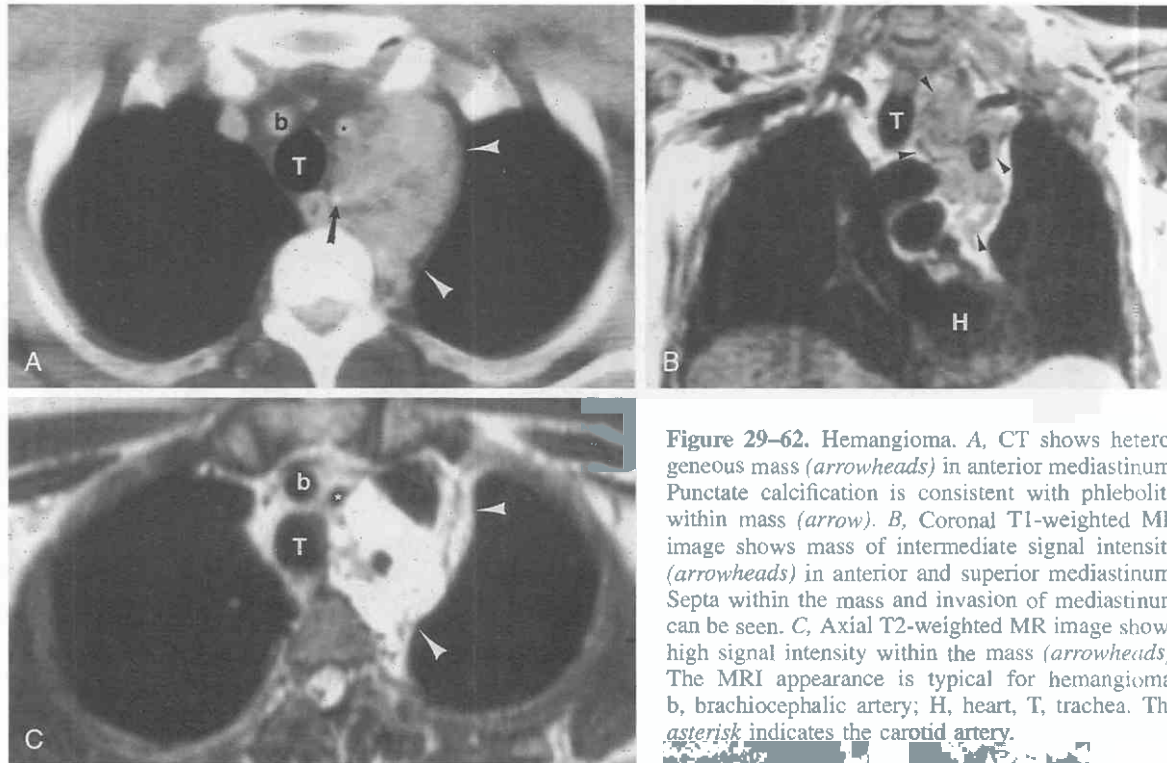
Hemangioma. A, CT shows heterogeneous mass (arrowheads) in anterior mediastinum. Punctate calcification is consistent with phlebolith within mass (arrow). B, Coronal T1-weighted MR image shows mass of intermediate signal intensity (arrowheads) in anterior and superior mediastinum. Septa within the mass and invasion of mediastinum can be seen. C, Axial T2-weighted MR image shows high signal intensity within the mass (arrowheads). The MRI appearance is typical for hemangioma. b, brachiocephalic artery; H, heart, T, trachea. The asterisk indicates the carotid artery.
